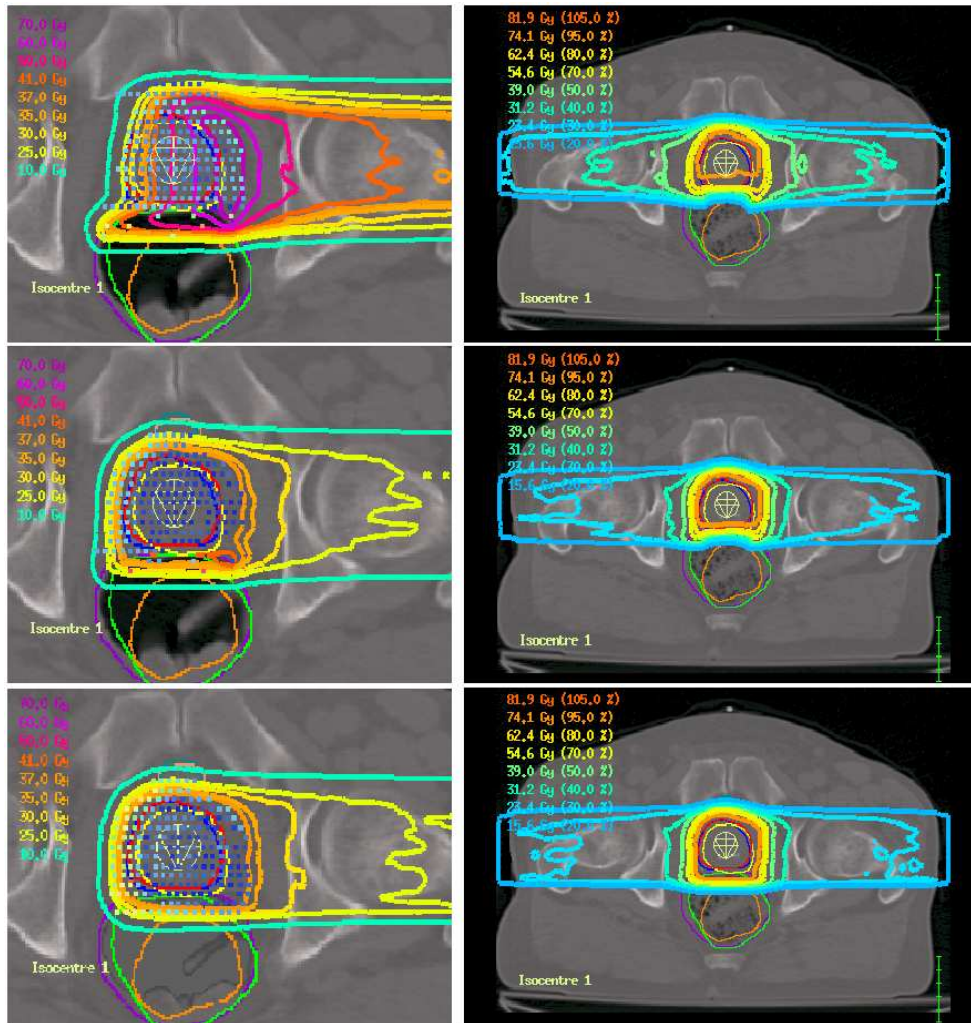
Left, the dose distributions of the original plan for patient C (planning CT number 2) for one field (Gantry  $90^\circ$ ) obtained with the different IMPT techniques - initial weights constant (top), initial weights corresponding to homogeneous PTV coverage for each field without (IMPT Sep) and with (IMPT W Sep) rectal gas water-equivalent density overwrite in the planning CT (middle, bottom). The colored points represent the Bragg peaks and the optimized beam weight (lowest = blue, highest = red). Right, the corresponding total plan dose distributions after recalculation on another CT (CT number 3).
